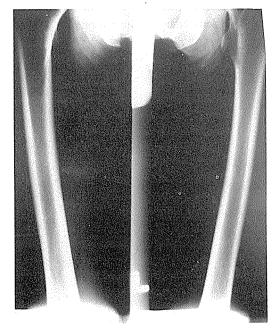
The radiographs of the lower limbs do not show the characteristic periosteal elevation of hypertrophic osteoarthropathy.³
